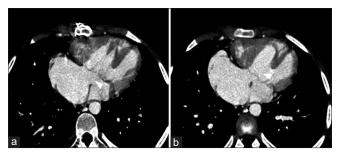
Atrial and ventricular septal defects. (a) axial section of computed tomography (CT) pulmonary angiogram image showing the atrial septal defect (arrowhead); (b) axial section of CT pulmonary angiogram image showing the ventricular septal defect (arrowhead)
